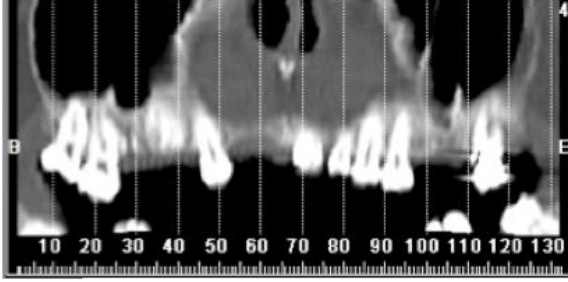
Panoramic image resulting of Dental CT evaluation. The elevated absence of teeth in the patient's upper maxillary is clearly shown.
